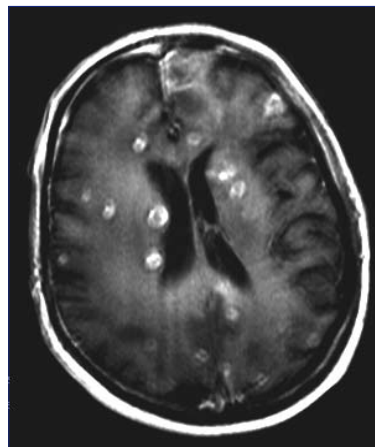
An MRI contrast enhanced T1 weighted image showing multiple ring enhancing tuberculomas in both frontal and parietal lobes.
